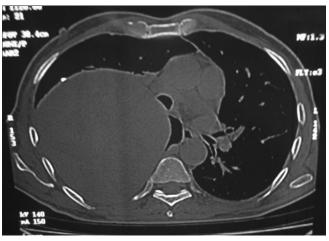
High resolution computed tomography scan of thorax revealed a huge right lung SOL, right pleural effusion and erosion of 4th rib
